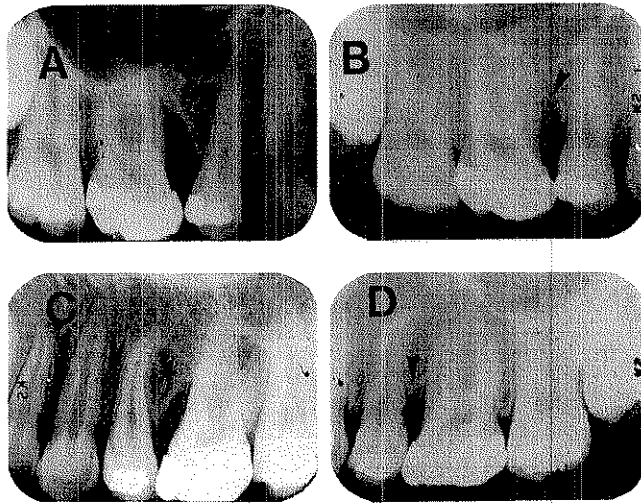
A,C. Case #4, radiographs of maxillary molars with vertical defects, May 1981. B,D. Case #4, radiographs after treatment revealing osseous fill, February, 1983.
